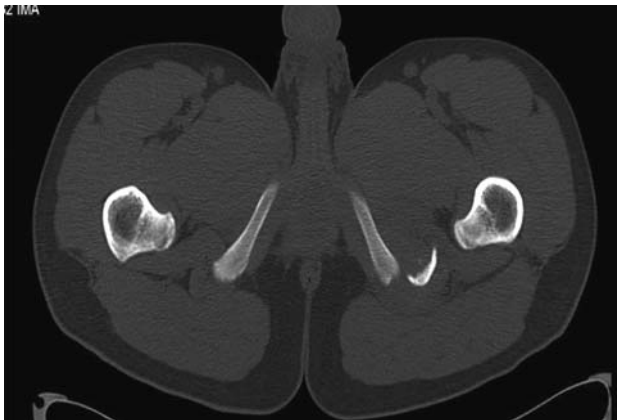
CT image showing the fragment displaced by 2.5 cm.
